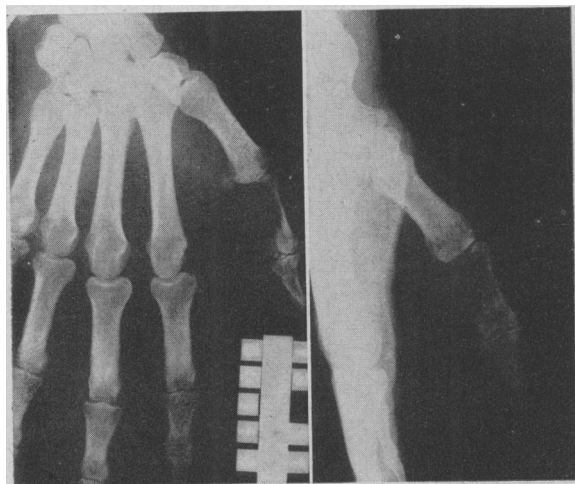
Radiograph of the thumb prior to first operation.
